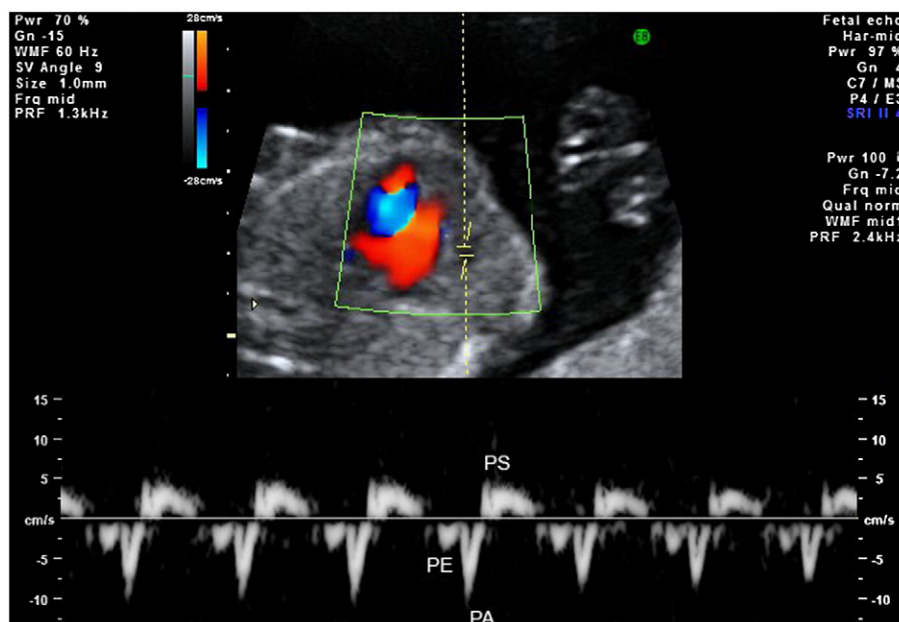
Doppler waveform of pericardial fluid showing bidirectional flow. Key: PS, systolic velocity; PE, early diastolic velocity; PA, late diastolic velocity.
